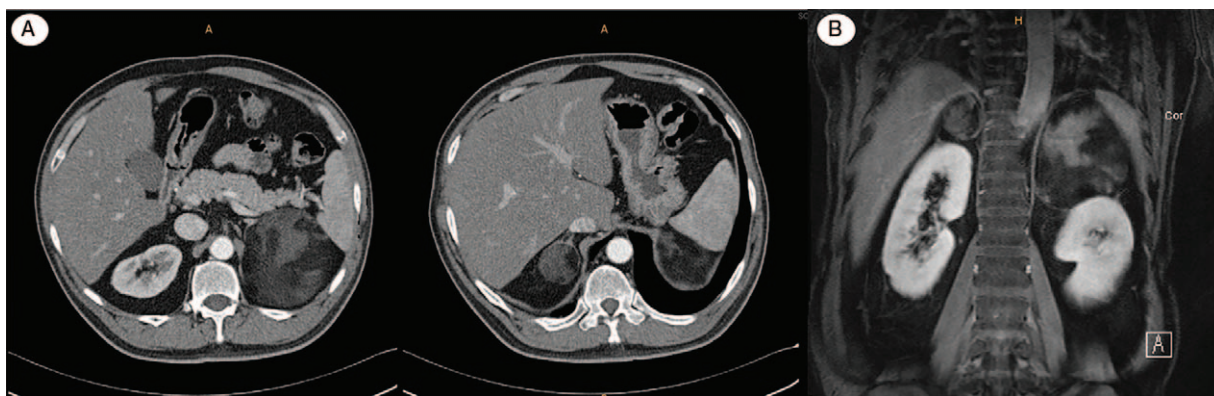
A, Abdomen and pelvic CT (C E) scan finding shows heterogenous fatty masses at both adrenal gland areas. B, Abdomen dynamic MRI (C E) scan finding shows $8.7 \times 8.0 \times 9.2$ cm left adrenal mass and $3.4 \times 3.0 \times 3.5$ cm right adrenal mass containing large amount of fat.
